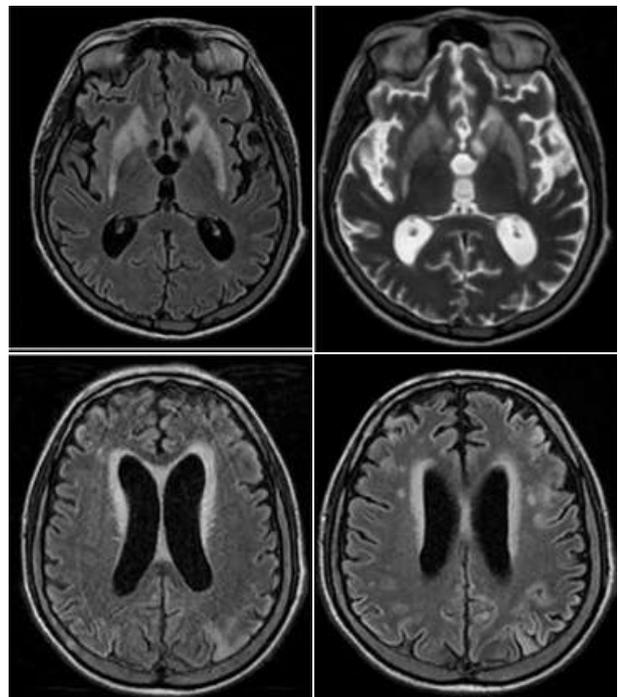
MRI Scan Brain (with FLAIR) showing T2WI hyper-intense signals in bilateral basal ganglia, brain atrophy, hyper-intense signals in periventricular, cortical, and sub-cortical regions
